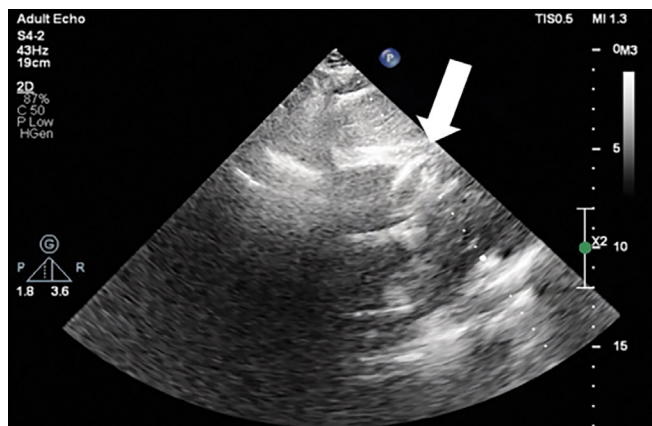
Transthoracic echocardiography (subcostal view) demonstrating a right ventricular lead position suspicious for myocardial perforation
